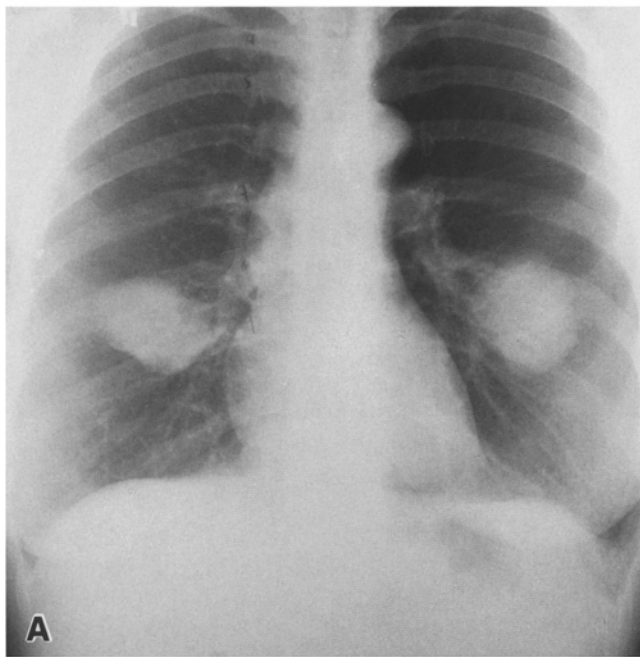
Chest X-ray showing a complete response of pulmonary metastases to six courses of ifosfamide and Adriamycin
